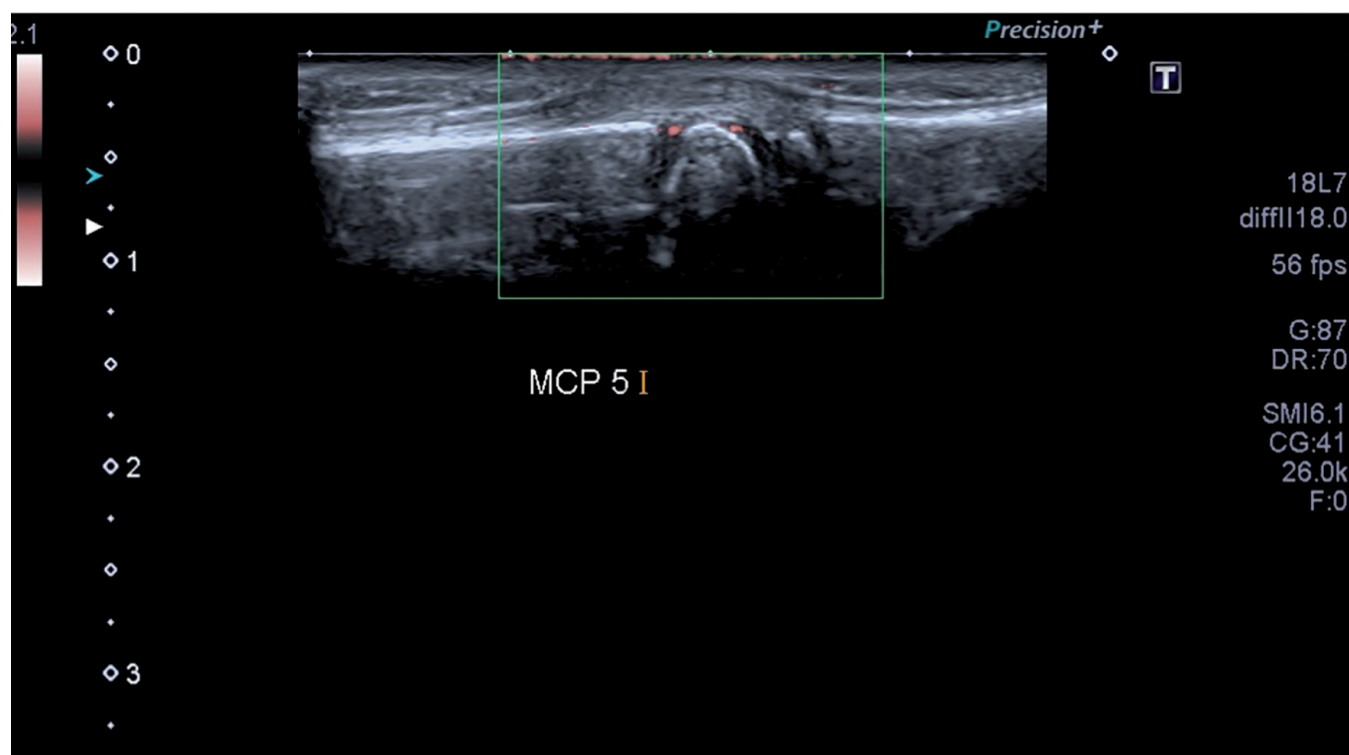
Dorsal B-mode ultrasound view of the fifth metacarpophalangeal (MCP5) and its vascularisation using PD-US. MTP5 joint of a 7-year-old boy. The proximal and distal physeal cartilage is anechoic. A signal is visualised in the proximal physeal cartilage and in the epiphyseal cartilage.
